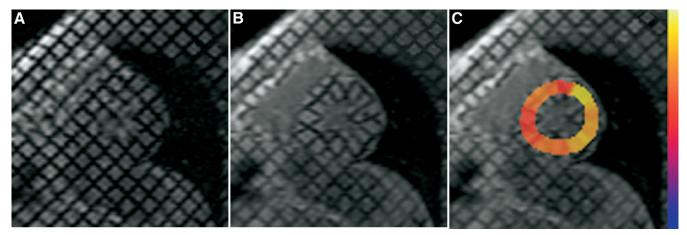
Tagged magnetic resonance images of a normal volunteer at LV midlevel at end-diastole (A) and end-systole (B). (C) The end-systole image is overlaid with a map of regional maximum shortening (0% shortening is mapped to blue, 25% shortening is mapped to yellow).
